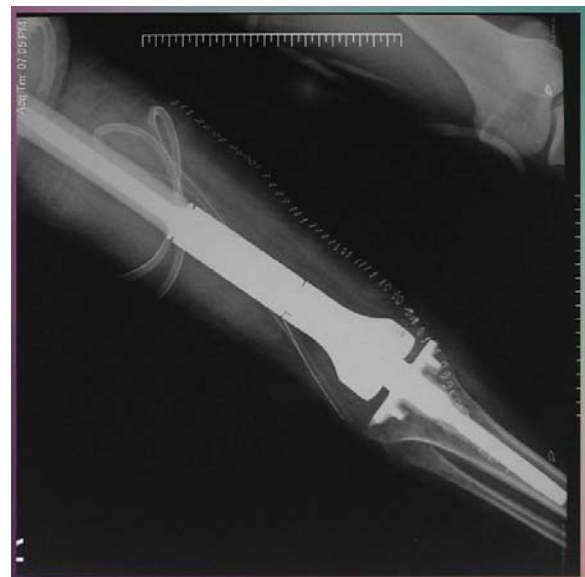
Post-operative xray showing megaprosthesis.
